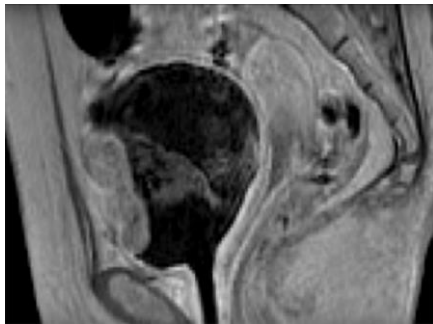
MRI (sagittal section) before the initiation of transurethral resection of bladder tumor shows a broad-based solitary nodular tumor on the anterior wall of the bladder with a diameter of 54 × 50 × 24 mm, indicating extracystic invasion, and no evidence of distant or lymph node metastasis.
